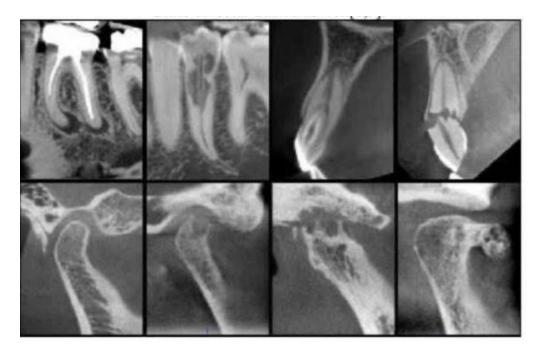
application of CBCT in endodontics courtesy:UCLA CBCT radiology images.
